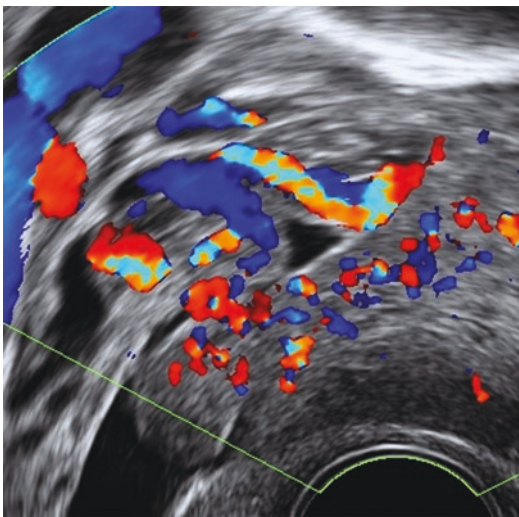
Color Doppler signals displaying a “lead vessel” which is sometimes observed in metastatic tumors
